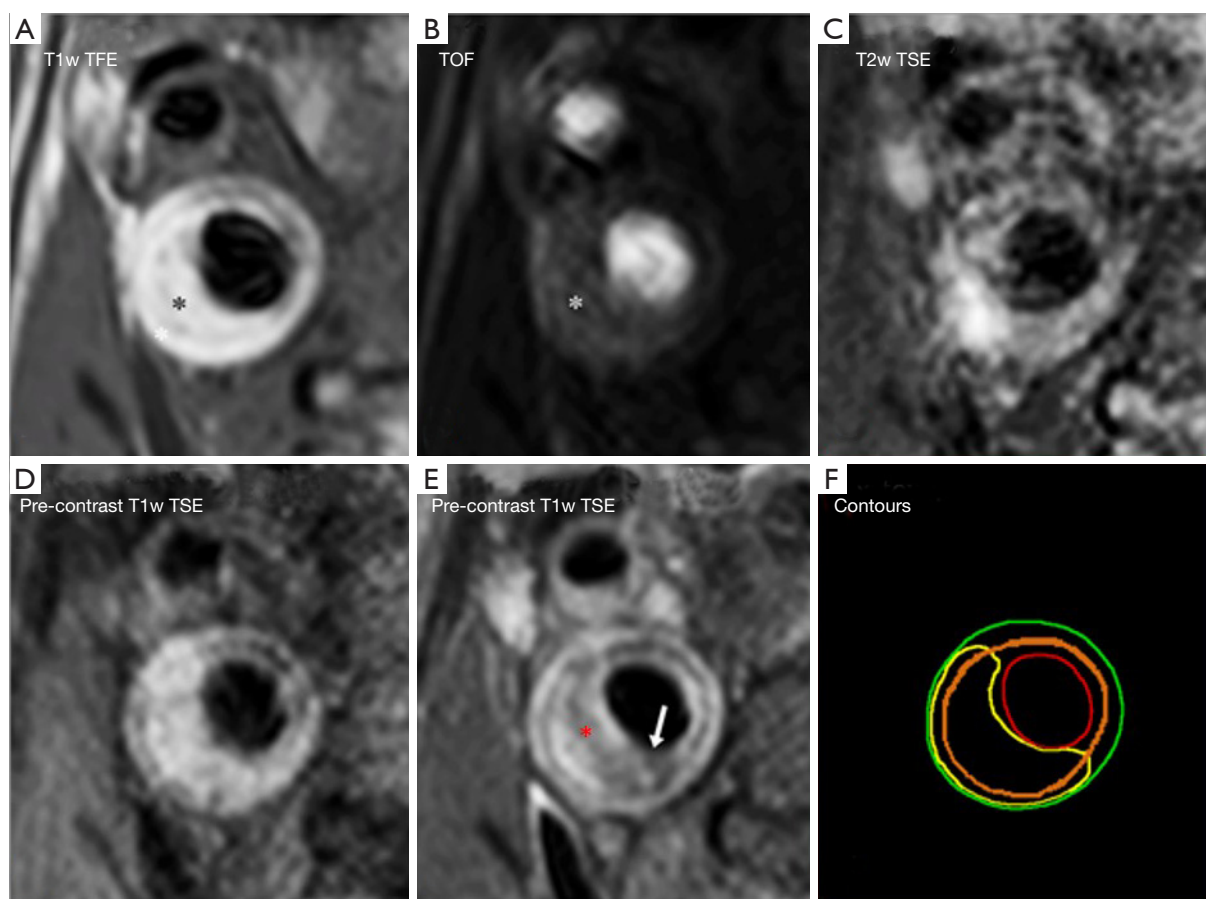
Co-registered (A) T1w TFE, (B) TOF, (C) T2w TSE, (D) pre- and (E) post-contrast T1w TSE images of a plaque in the internal carotid artery; (F) displays the delineation of plaque components and the inner and outer vessel wall: red = lumen; green = outer vessel wall; yellow = LRNC; orange = ring of calcifications; remaining vessel wall area = fibrous tissue. Hyperintense signal in A, and high signal in B (with respect to surrounding muscle tissue) in the bulk of the plaque is indicative for IPH (asterisk in T1w TFE and TOF images). A ring of hypointense signal, indicative for calcifications, is observed in all weightings [orange in (F)]. The lipid-rich necrotic core (yellow contour) can be identified as a region within the bulk of the plaque which does not enhance on black blood T1w MRI [red asterisk in (E)]. The fibrous cap can be recognized as a region with signal enhancement on the post-contrast images between the lipid-rich necrotic core and the lumen. This region with enhancement is interrupted, indicating a thin or ruptured fibrous cap [arrow in (E)]. [Images reproduced with permission from Kwee *et al.* (22)].
